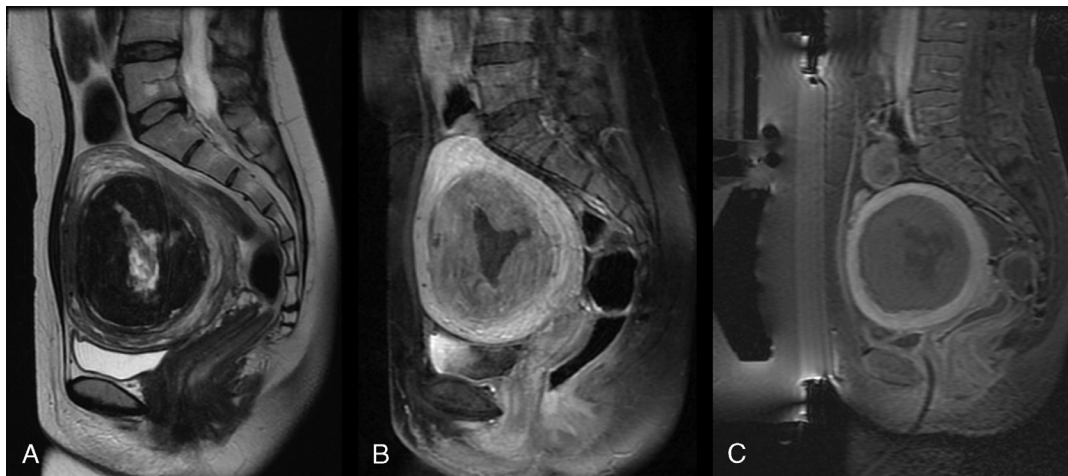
A 45-year-old woman with a 418-cm³ fibroid experiencing gradually worsening pelvic pressure and hypermenorrhea. A, Sagittal T2w MR image obtained before treatment shows predominantly hypointense fibroid (type 1) with hyaline degeneration of the central area. B, Sagittal contrast-enhanced fat-suppressed MR image before treatment shows homogeneous enhancement of vital fibroid tissue. C, Sagittal contrast-enhanced fat-suppressed MR image acquired immediately after treatment shows a completely nonperfused fibroid tissue.
